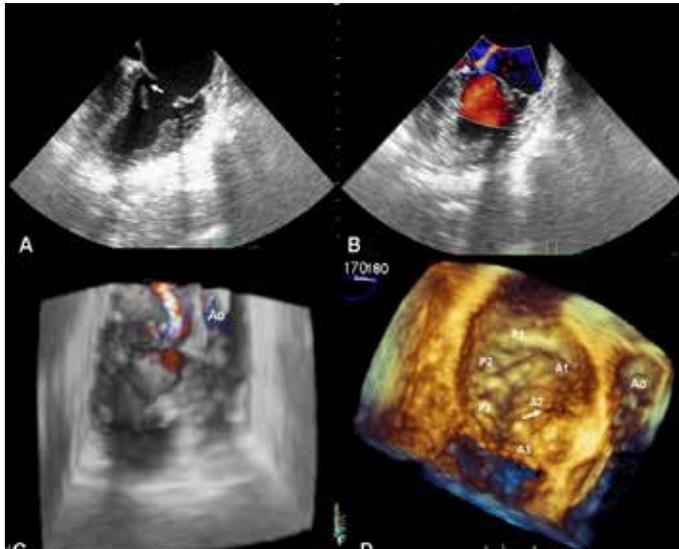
2-D TEE views showing a perforation on the anterior mitral valve (A), color Doppler 2-D TEE views revealing a mitral regurgitation resulting from this perforation (B), 3-D color full volume TEE confirmed mitral regurgitation at the anterior mitral leaflet (C) and 3D Live Zoom acquisition revealed the cleft at A2 scallop
